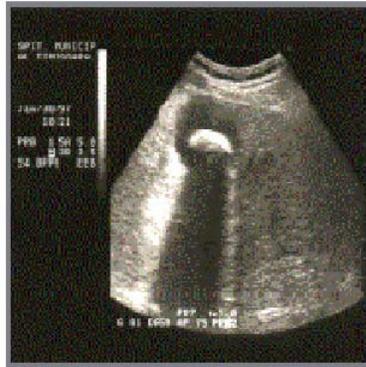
Ultrasound highlighting of gallstones
